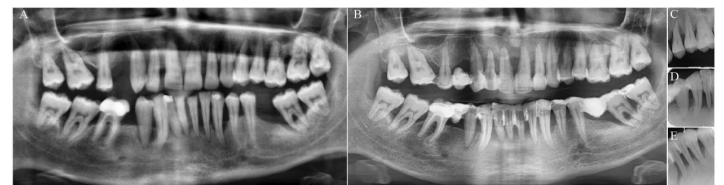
(A) Initial panoramic radiography of Case-2 showed generalized bone loss. B) Panoramic radiography taken 1-year after. C) Periapical radiographs at 1-year visit. No disease progression both clinically and radiographically was detected.
